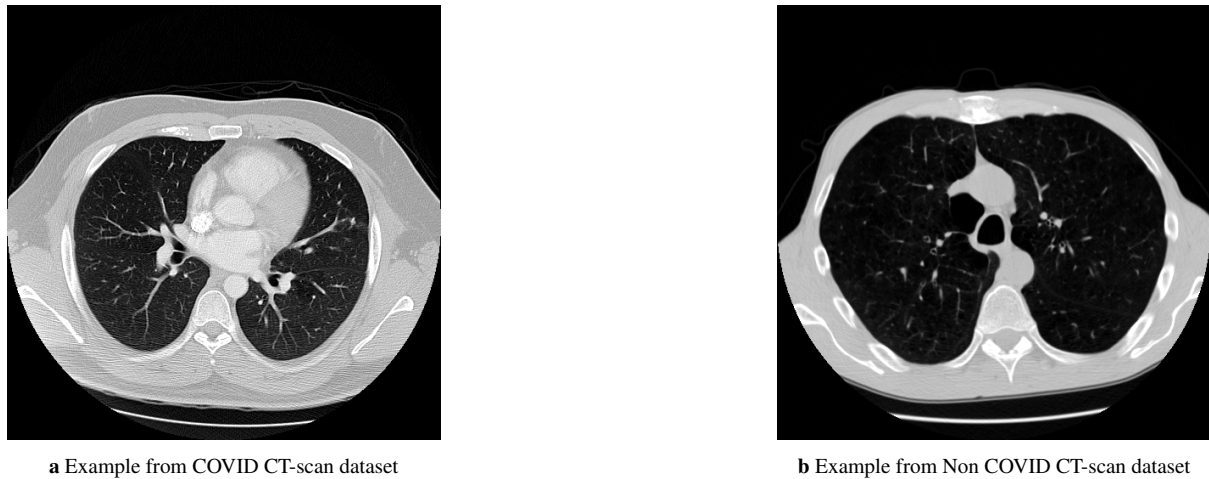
Examples from CT-scan dataset [10].
